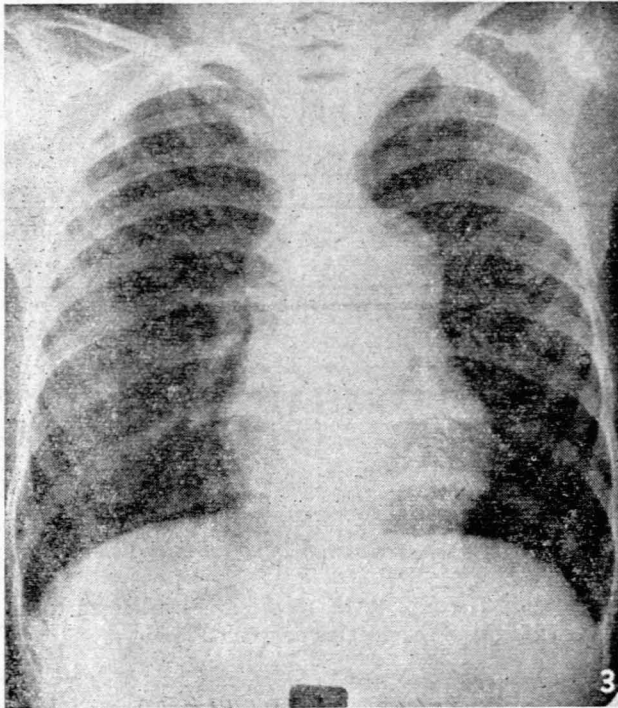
Chest Roentgenogram. Note the full pulmonary arc and normal lung fields.
